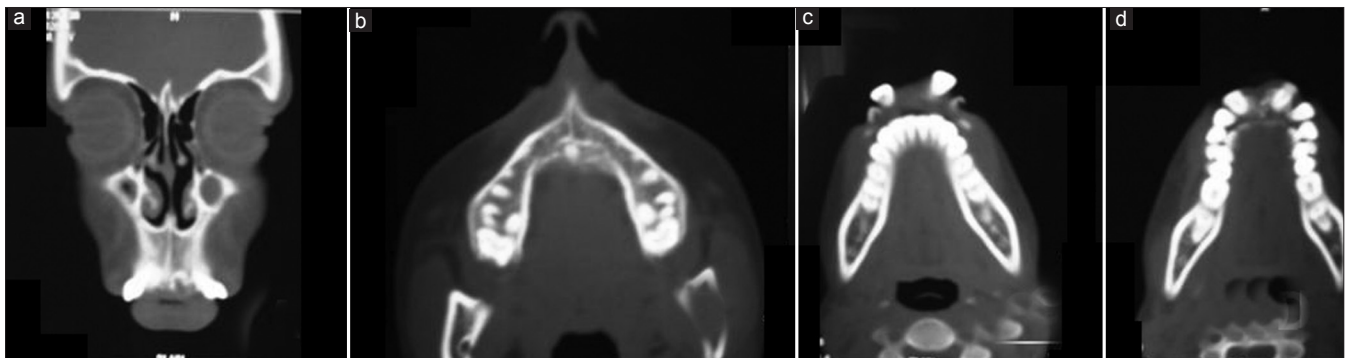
CT scan revealing an ill-defined, coarse, irregular trabecular bone pattern superimposed over the anterior maxillary permanent teeth
